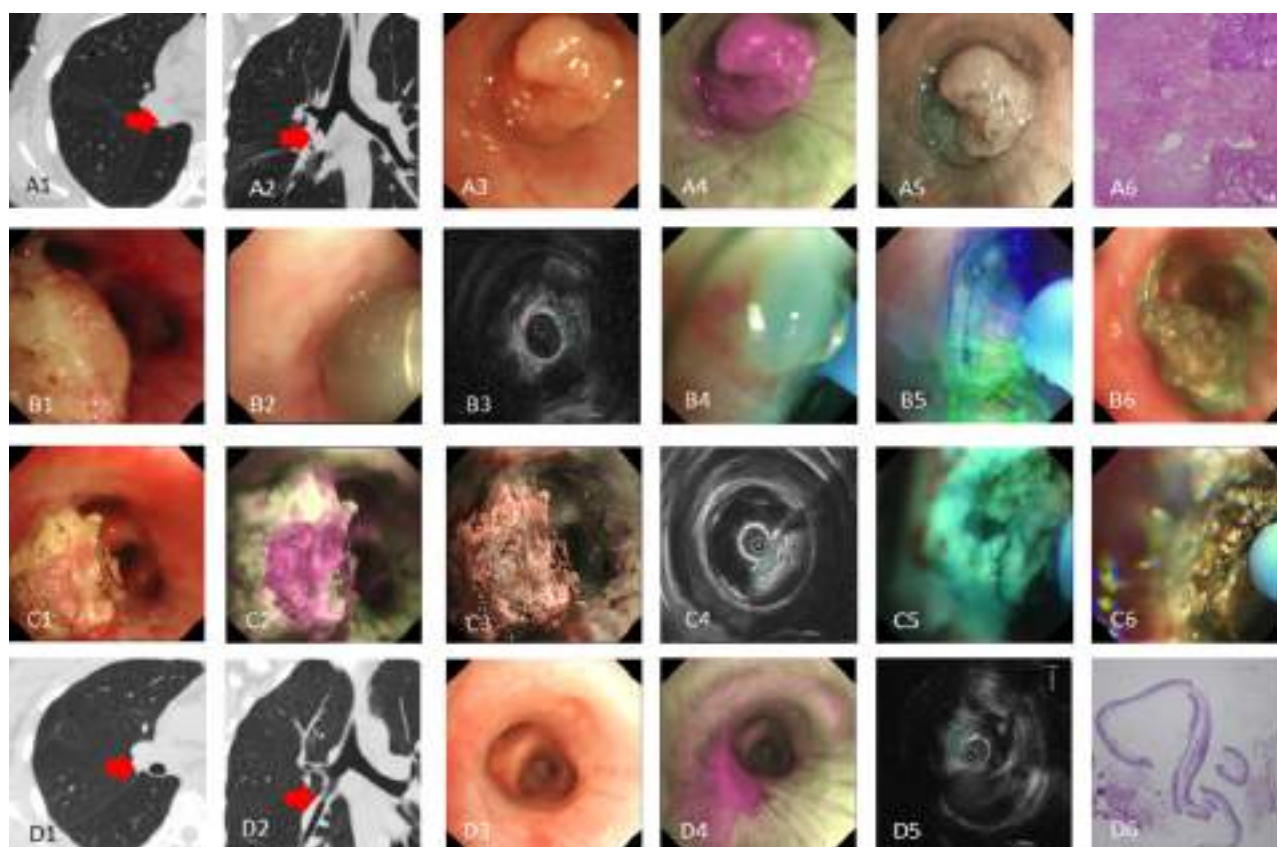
Hybrid-Argon Plasma Coagulation (APC) therapy in the treatment of an adult patient with tracheobronchial mucoepidermoid carcinoma. CT showed a nodule in intermediate bronchus, completely obstructing the airway (A1-2); large neoplasm in the intermediate bronchus detected by WLB, AFI, and NBI (A3-5); pathologic images indicated MEC (A6-8); invasion size evaluated by rpEBUS after snare incision (B1-3); light blue water cushion created by Hybrid-APC (B4); Hybrid-APC ablation (B5-6); bronchoscopic inspection by WLB, AFI, and NBI, and evaluation by rpEBUS after first Hybrid-APC therapy (C1-4); light blue cushion created by Hybrid-APC (C5); 2nd Hybrid-APC ablation (C6); CT scan at 4-month follow-up revealed no recurrence (D1-2); bronchoscopy reexamination by WLB and AFI and invasive evaluation by rpEBUS at 4-month follow-up (D3-5); pathologic images at 4-month follow-up revealed no recurrence (D6).
